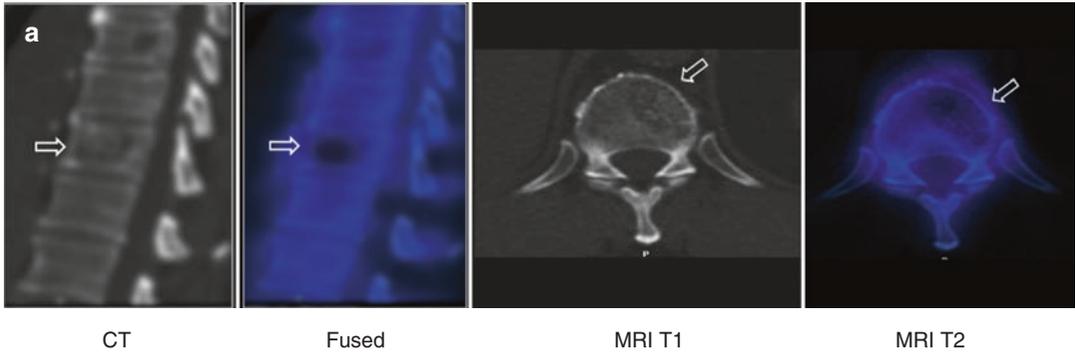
Vertebral hemangioma on a Tc-99m MDP SPECT/CT study (a) showing another scintigraphic pattern of the tumor of photon deficiency corresponding to the CT abnormality (arrows). MRI (b) of the same tumor shows the characteristic appearance
